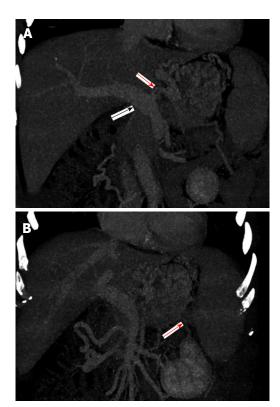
Enhanced computed tomography scan. A: An enlarged portal vein from the origin of the gastric coronary vein and an enlarged, circuitous gastric coronary vein; B: Splenic vein flow signals in the portal venous phase are absent.
